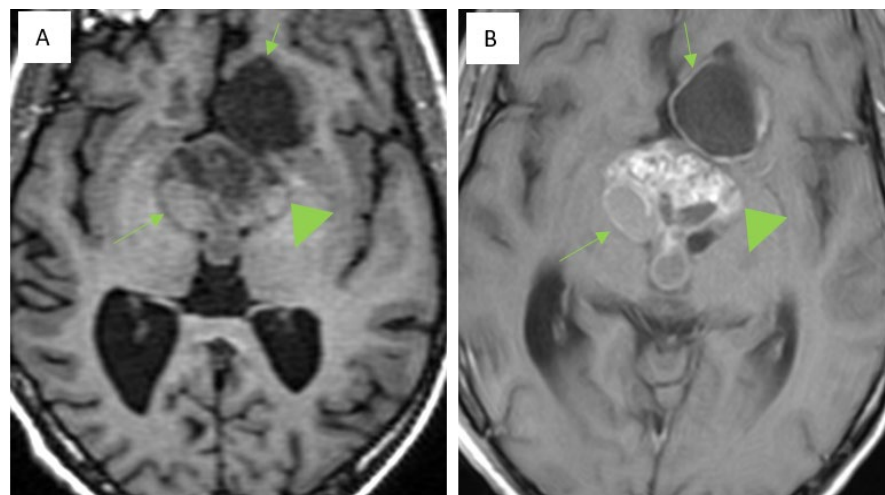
T1-weighted MRI before (A) and after (B) gadolinium administration in a 17-year-old male patient with growth and visual disturbances, showing a heterogeneous craniopharyngioma. The solid component shows punctate signal voids (arrowhead), and the cystic components show no enhancement (arrows).
